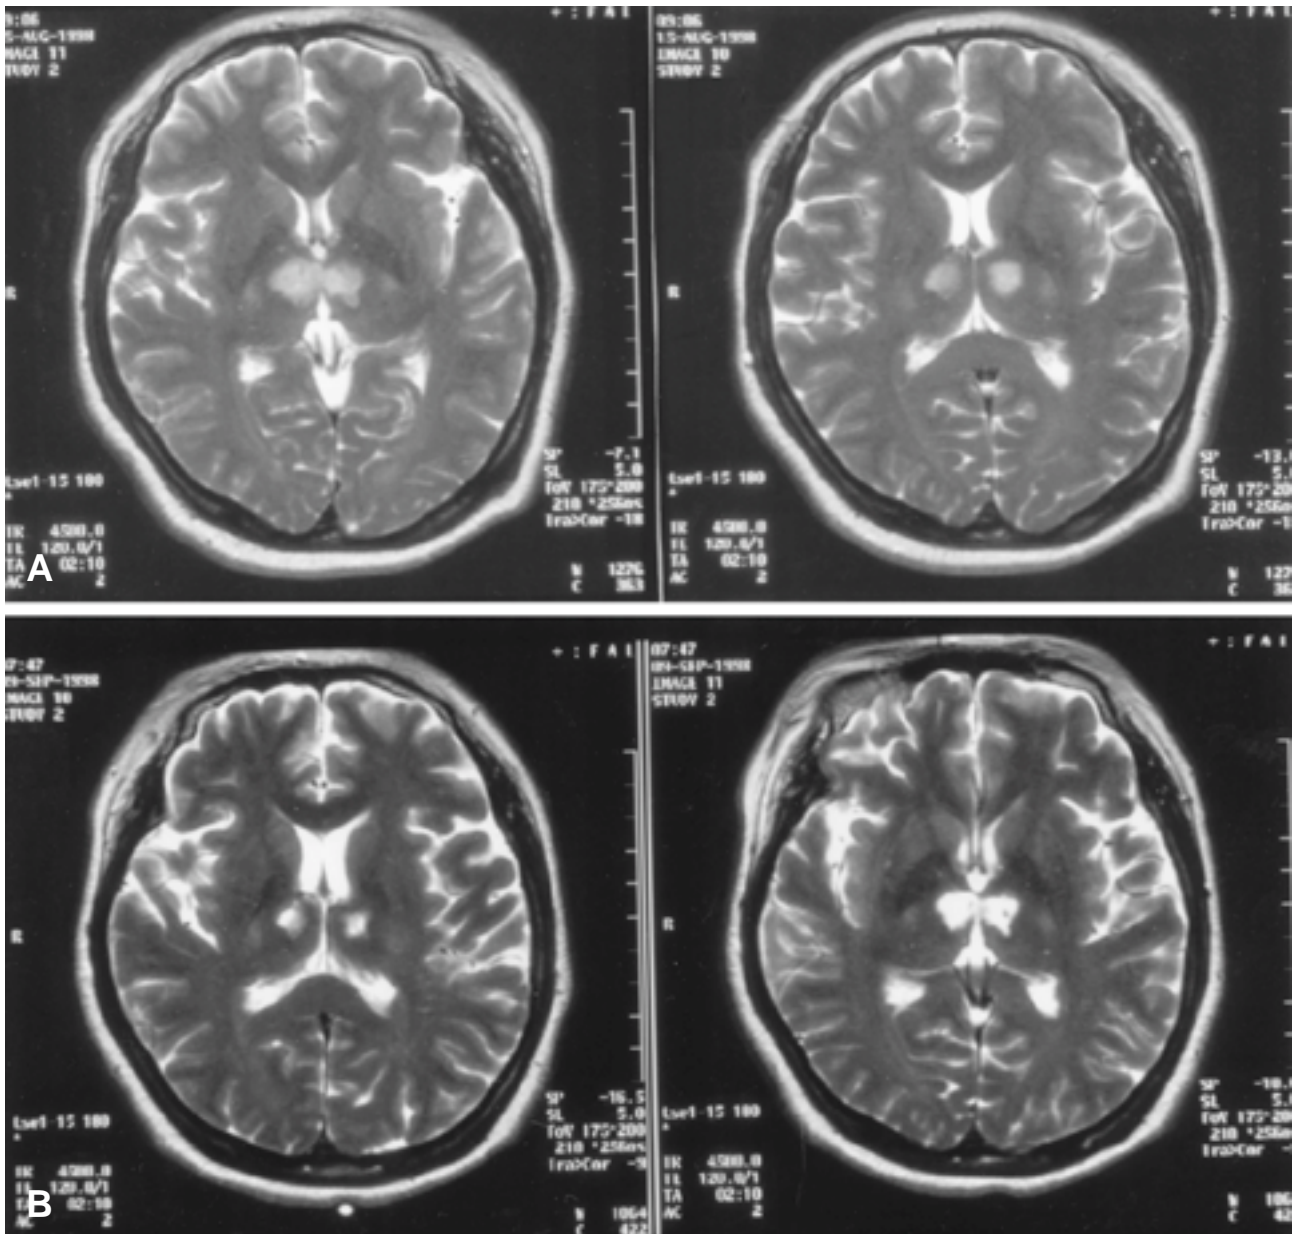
T2 weighted axial brain MR image shows high signal intensity on bilateral thalamus.(1 day after the onset of stroke)
